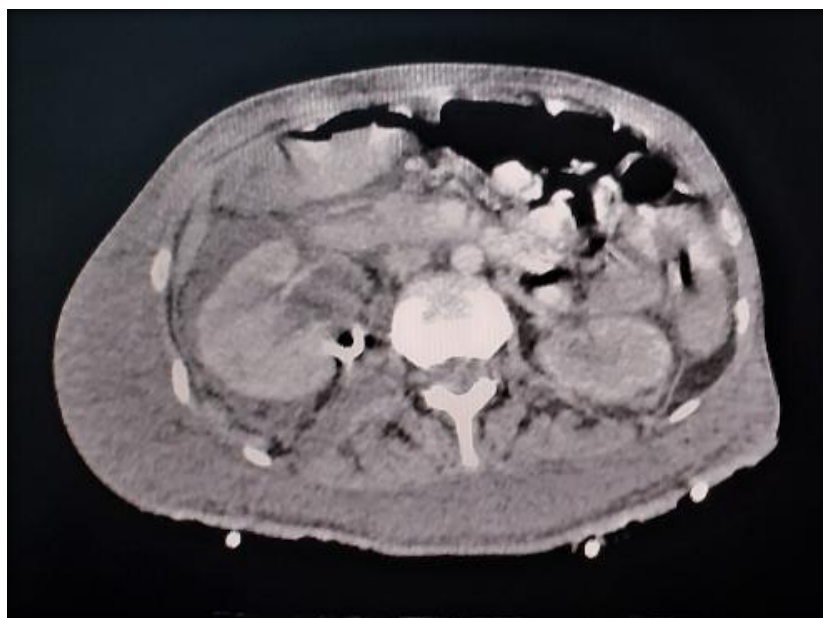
A thoraco-abdomino-pelvic CT scan was performed in this patient, demonstrating a moderate right-sided pleural effusion and a right perirenal collection suggestive of a urinoma. The distal tip of the right catheter was visible in an extrarenal and right subdiaphragmatic position, with identification of a largely necrotic centropelvic mass showing locoregional infiltration responsible for bilateral ureterohydronephrosis.
